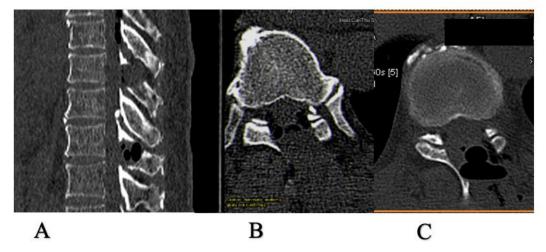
CT-Scan Sagittal image of the injured thoracic vertebra levels have been decompressed (A); CT Scan Axial image of T8-T9 level (B) and T10-T11 level (C) have been decompressed.
